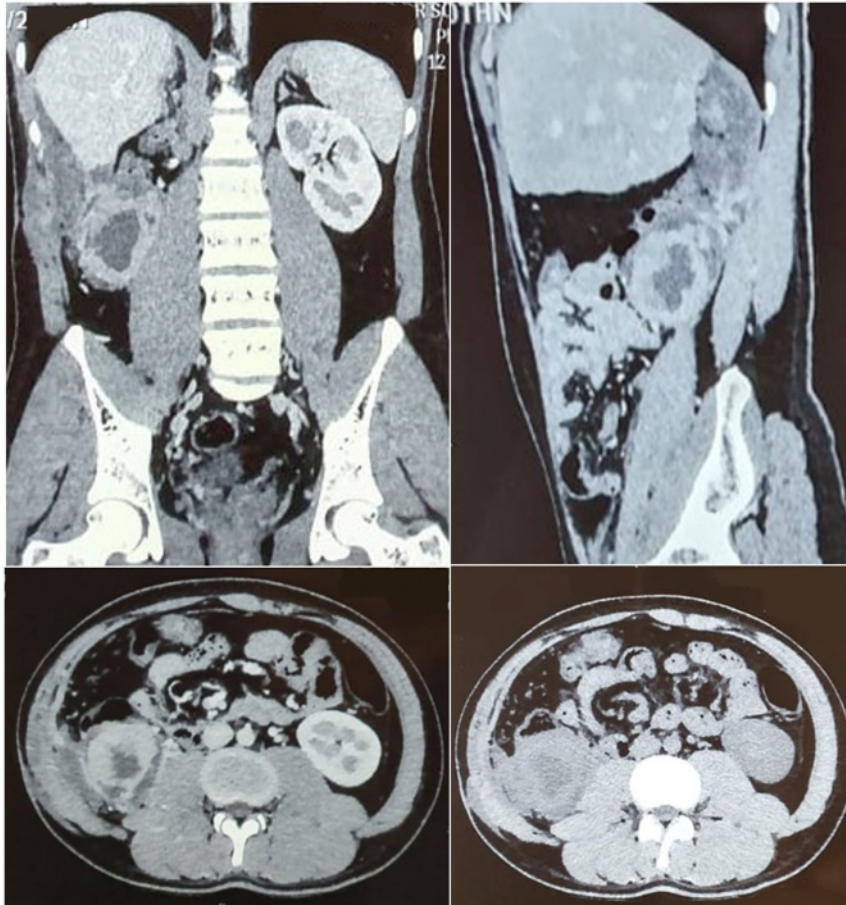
Abdominal CT-scan twelve months after 6 cycles of chemotherapy (R2).
